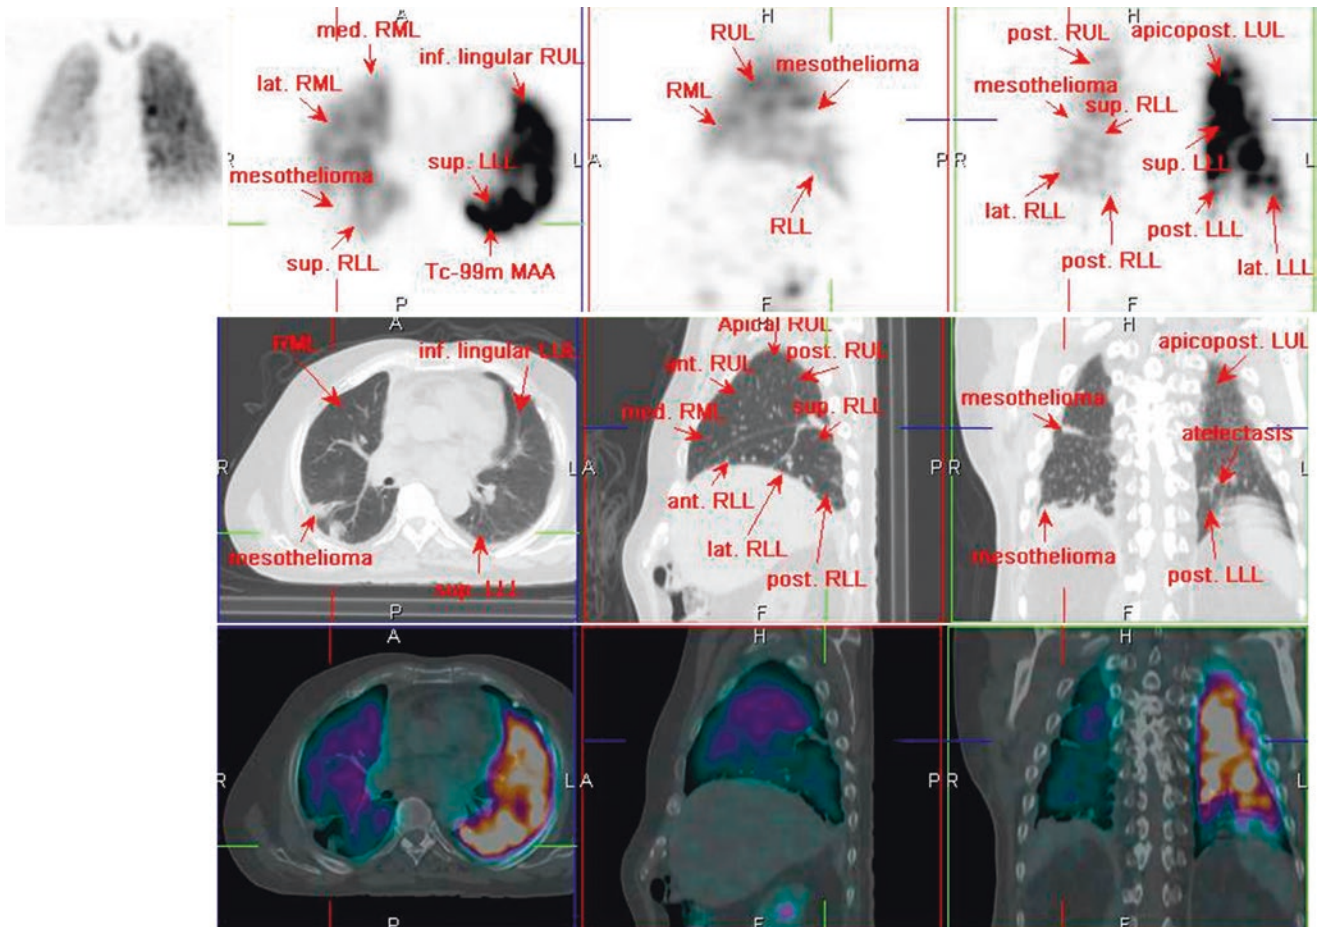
^{99m}Tc-MAA SPECT/CT
